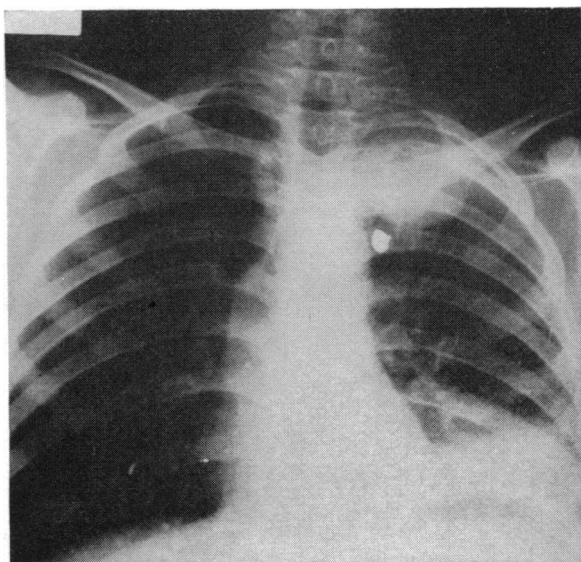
case no. 11. The chest X-ray of a boy aged 14 following a missile injury to the superior mediastinum. The retained missile and the pulmonary shadow consistent with a left subclavian aneurysm are demonstrated.
